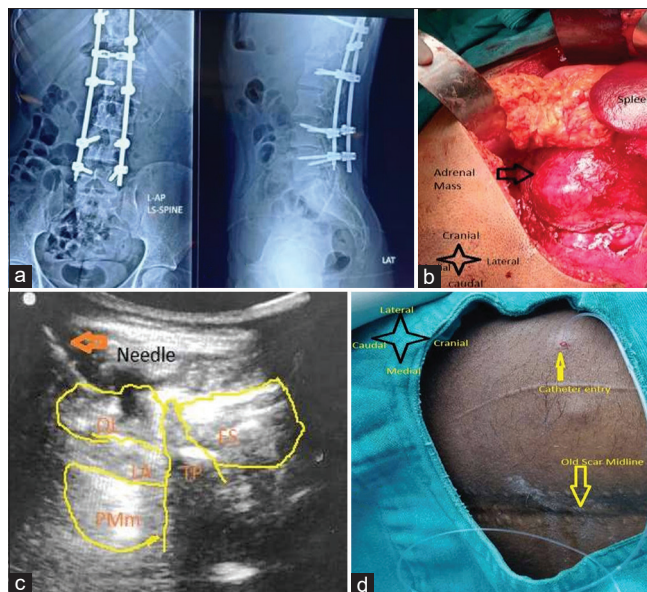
(a) Figure showing preoperative spine radiograph (anteroposterior view) and lateral view of scoliotic correction. (b) Intraoperative image showing large left adrenal mass. (c) Ultrasound image with needle direction and spread of local anesthetic (LA) anterior to the quadratus lumborum muscle (QL). TP-Transverse process of the L3 vertebra, ES- Erector spinae muscle, PMm- Psoas major muscle. (d) Figure showing catheter entry point and old scar of the scoliosis surgery
